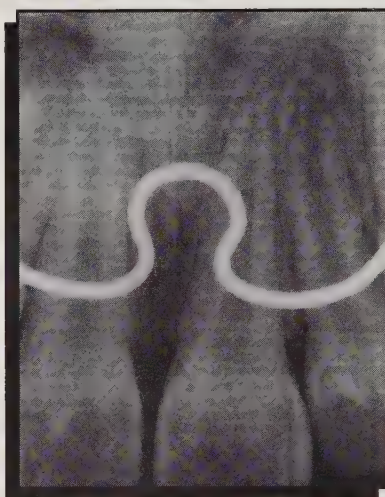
Panel A, clinical anterior view of the permanent dentition at age nine. Panel B, periapical radiograph of the upper anterior. Panel C, periapical view of the lower anteriors. No clinical or radiographic evidence of periodontal disease was noted at this time.
